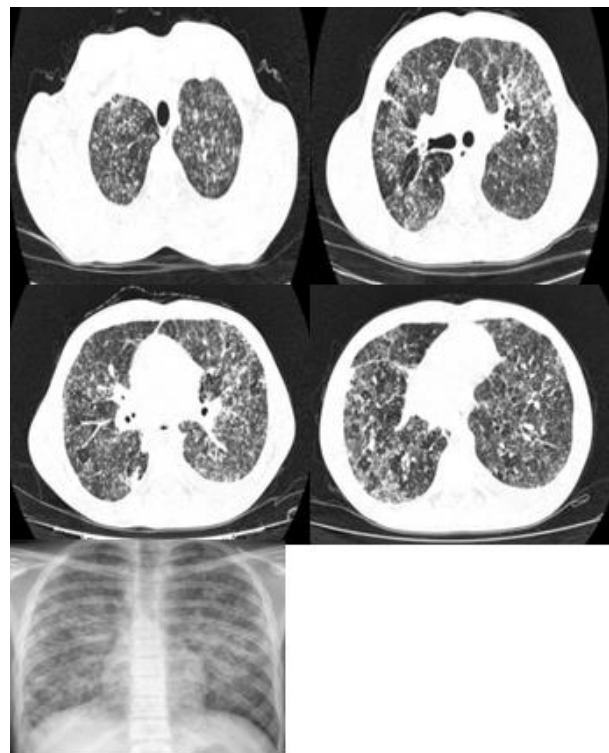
Admission chest radiography and chest computed tomography
